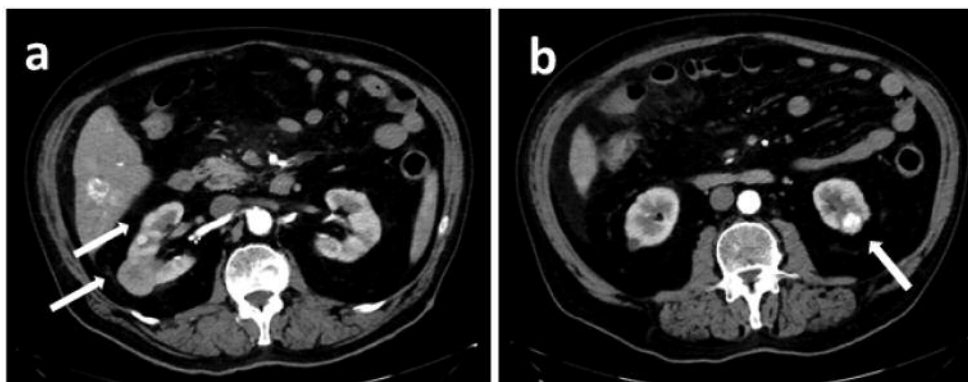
Abdomen computed tomography scan.
